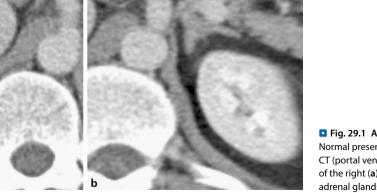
Adrenal gland, normal findings. Normal presentation of both adrenal glands in CT (portal venous phase). Typical V-configuration of the right (a) and Y-configuration of the left (b) adrenal glands
